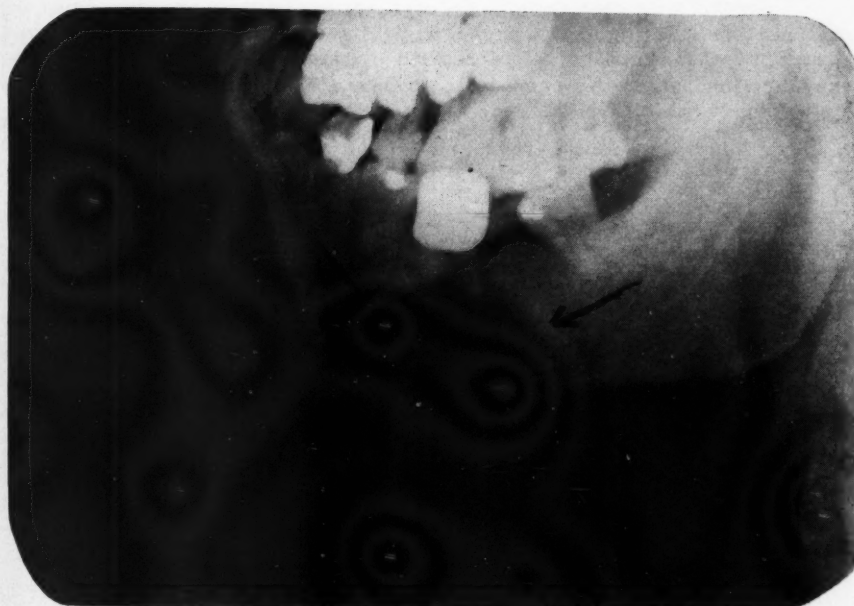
A LARGE CYST OF THE LOWER JAW. A cyst is a circumscribed cavity with a well defined, organized lining membrane or sac, containing a fluid or semifluid substance, which may be either sterile or infected. Patients are usually unaware of the presence of a cyst until it is revealed by the "x-ray." As a rule they are painless unless infected. Their early discovery and removal is important, as fractured and disfigured jaws are often the result of undetected cysts.
